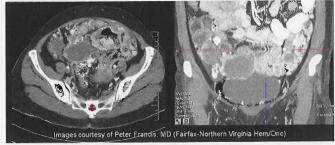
Initial CT scan of pelvic and abdominal masses
